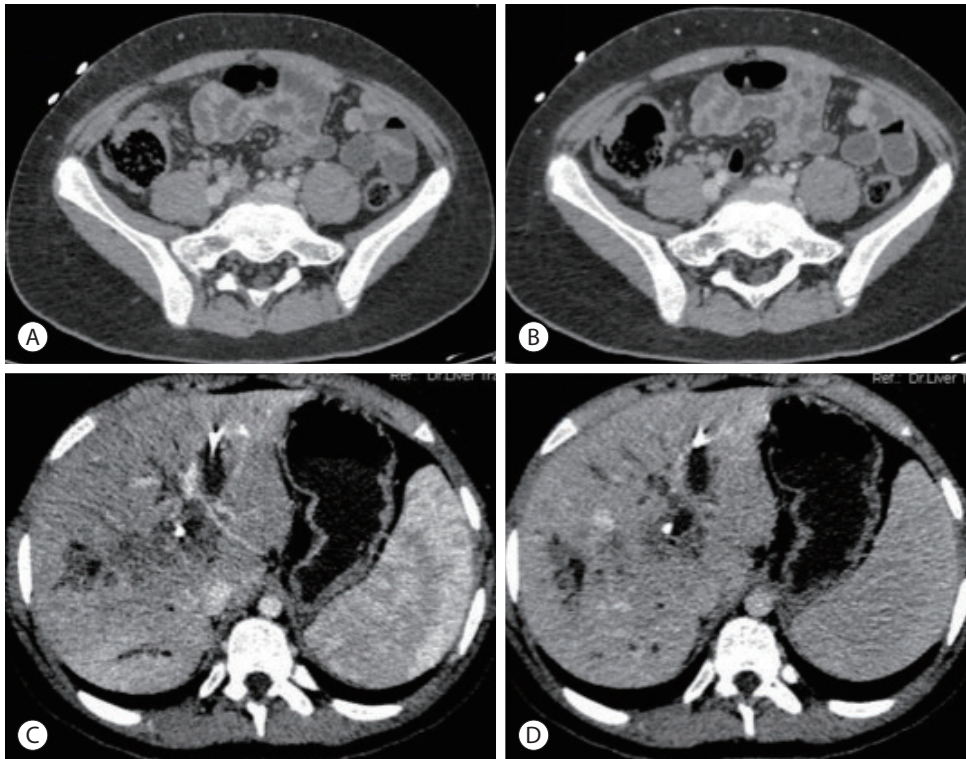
(A, B) The triphasic follow-up contrast-enhanced computed tomography scan demonstrates interval resolution of the irregular, ileocecal thickening and paracecal lymph nodes (porto-venous phase). (C) Arterial, (D) porto-venous phase. There was an interval reduction in the size of the liver lesions.
